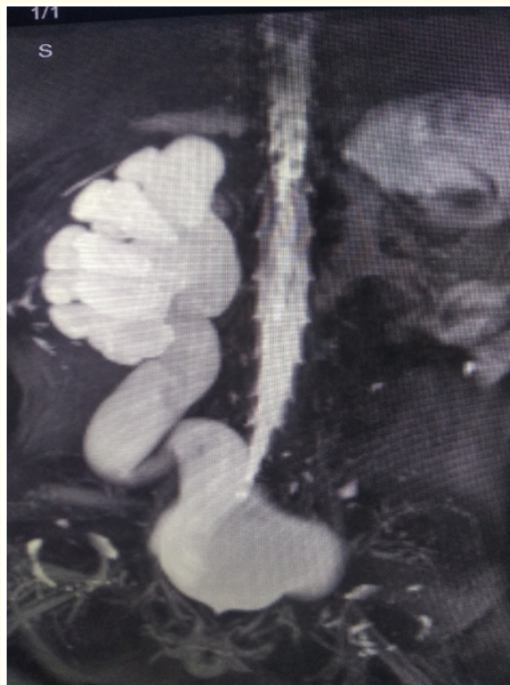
MRI showing the enlargement of the right kidney with reduction of cortical thickness and giant pelvis and ureter just before the ureterovesical junction.
